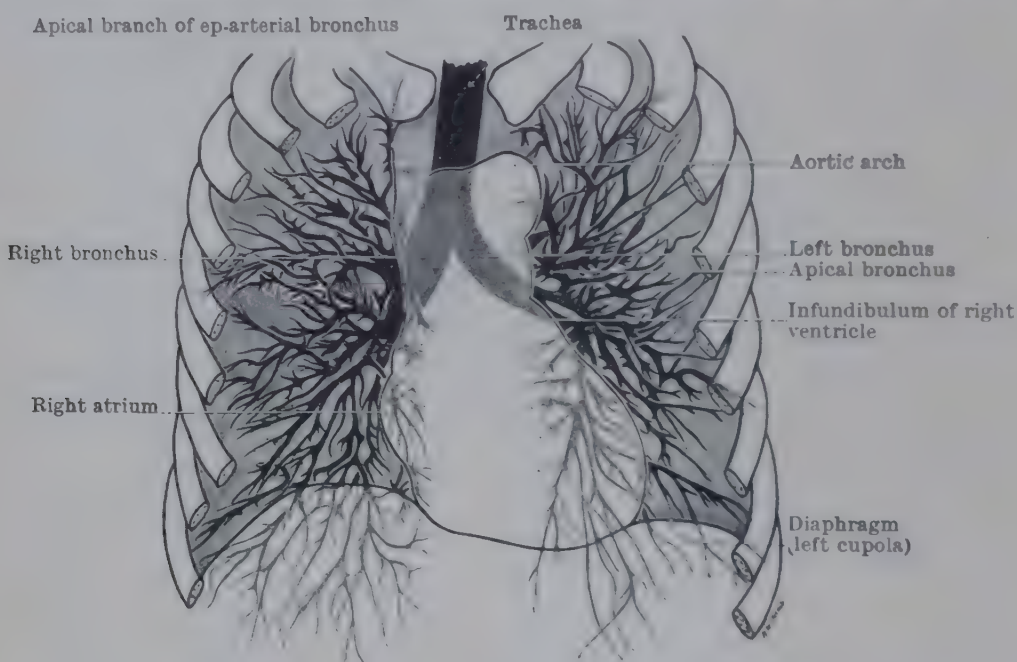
TRACING FROM RADIOGRAPH OF CHEST IN FULL INSPIRATION.
